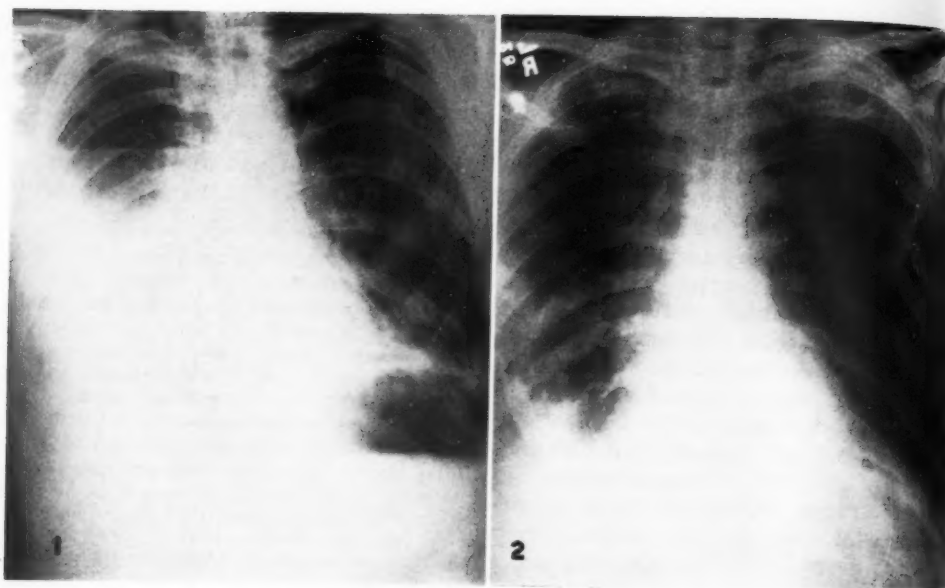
Case I. Roentgenogram of chest showing right hydropneumothorax, mediastinal emphysema, and parenchymal infiltrates.
